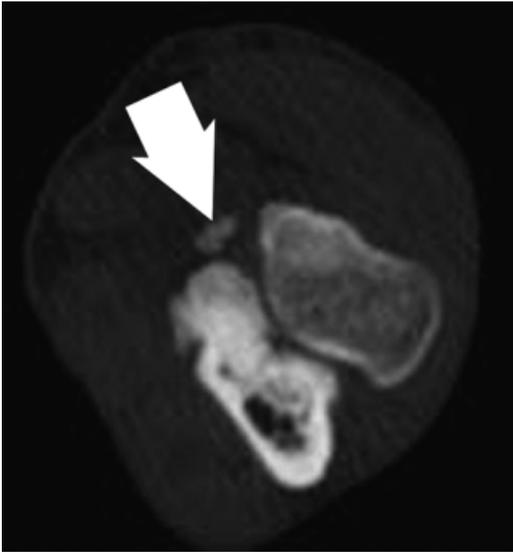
Transverse computed tomography (CT) of an abnormal shape of the medial coronoid process (MCP) with a distinct fragment (arrow) and irregularity of the radial incisure (courtesy of Dr. Kristen O'Dell).
